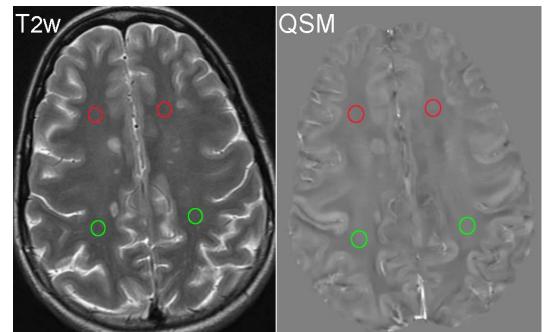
Example of ROIs approximately 50mm^2 placed over the NAWM in bilateral frontal (red circles) and parietal (green circles) white matter on T2-weighted and QSM images.
